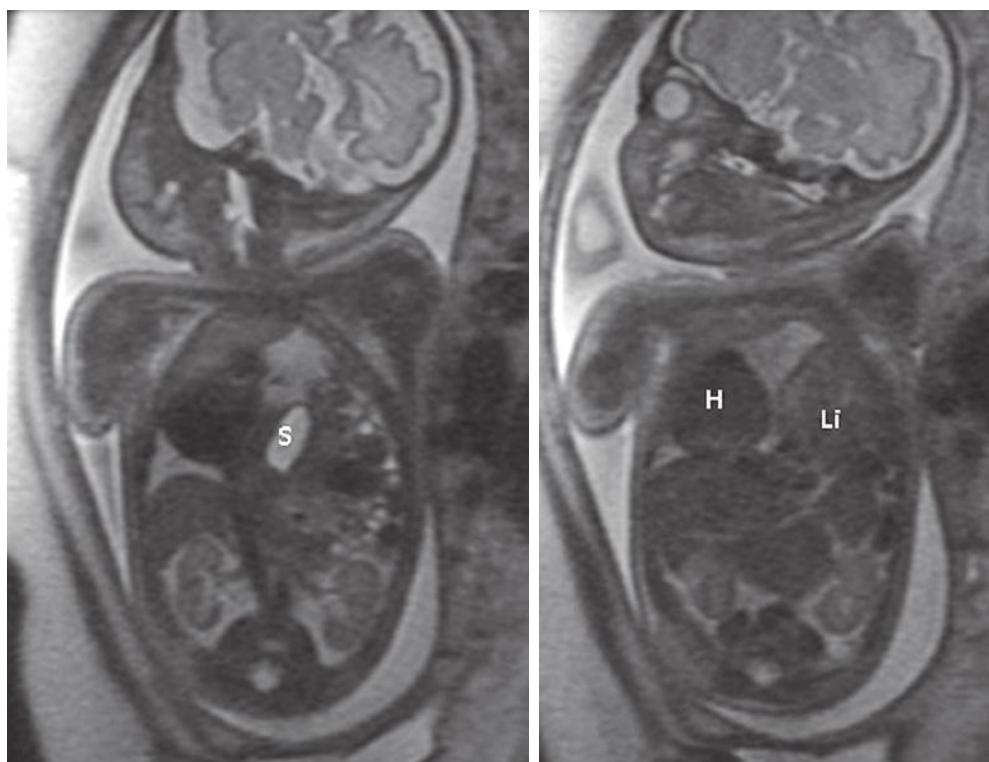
Fetal left congenital diaphragmatic hernia shown on coronal T2-weighted images. Fluid-filled stomach (S) is noted within the left hemithorax with rightward shift of the heart (H). High signal intensity lung tissue can be visualized and distinguished from herniated contents including portion of left lobe of the liver (Li).
